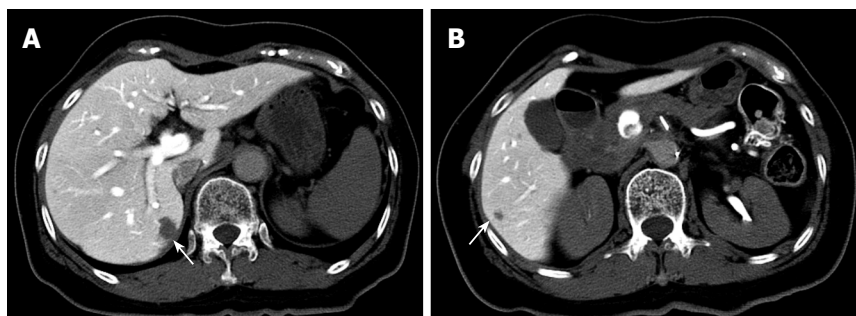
CT during arterial portography showing hypointense nodules. A: 10 mm nodule in segment 7; B: 4 mm nodule in segment 6.
